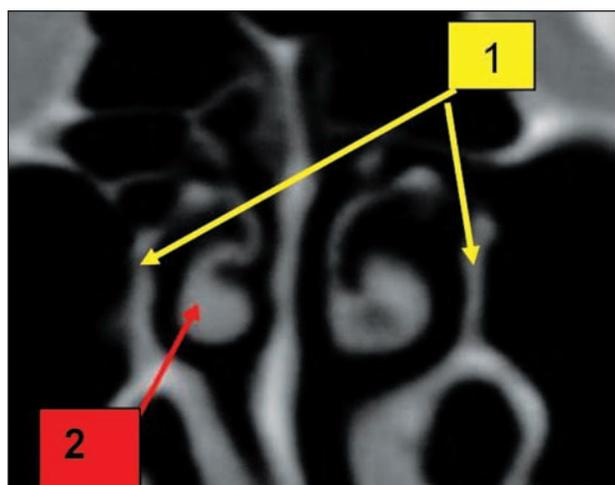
Paranasal sinuses CT scan, bone window, coronal slice. 1. Bilateral verticalization (lateralization) of the uncinete process; 2. Paradoxical curvature of the middle turbinate
